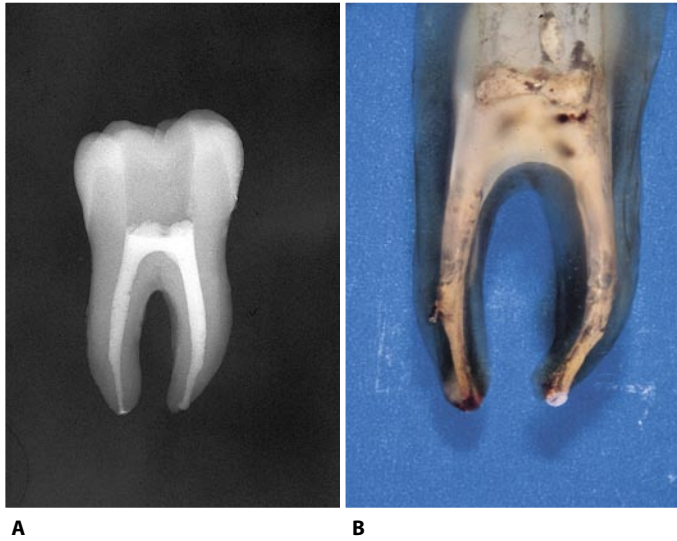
A. Radiograph of a lower first molar correctly obturated "in vitro" with thermoplastic gutta-percha. B. The same tooth after decalcification and clearing.
